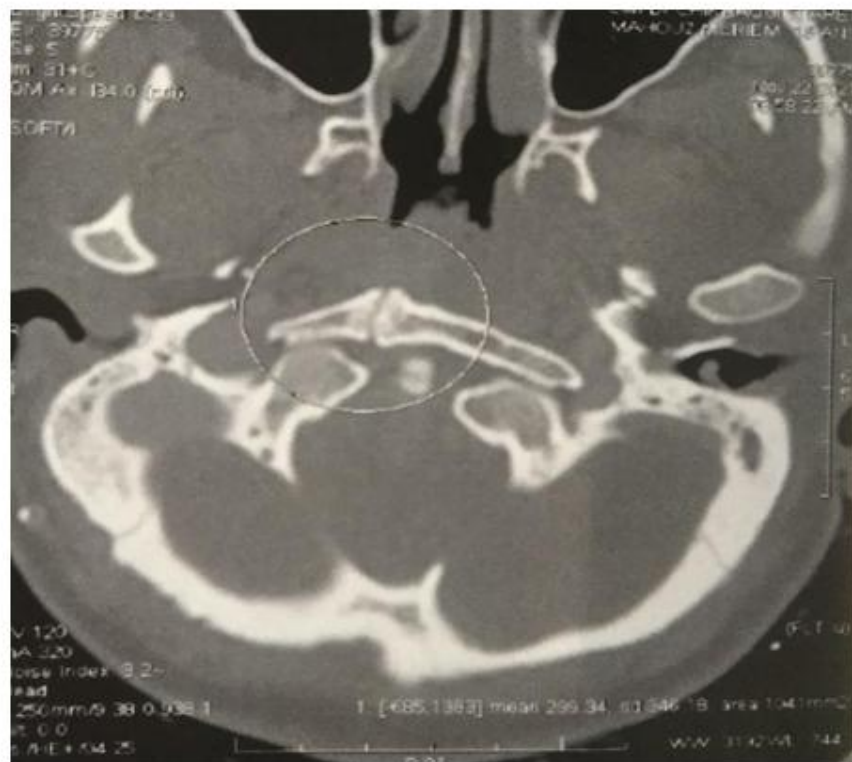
computed tomographic (CT) scan showed an absence of fusion of the anterior arch of C1.
